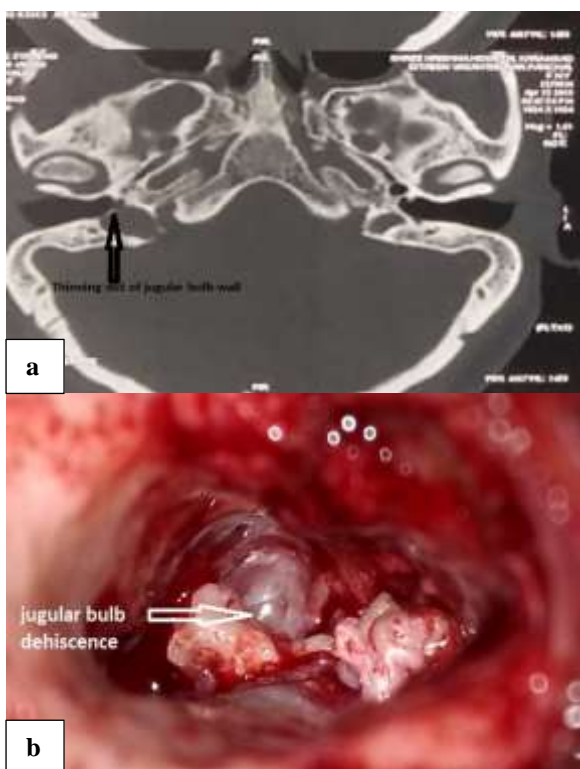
(a) axial image of HRCT showing jugular bulb dehiscence; (b) intraoperative finding showing jugular bulb dehiscence.
